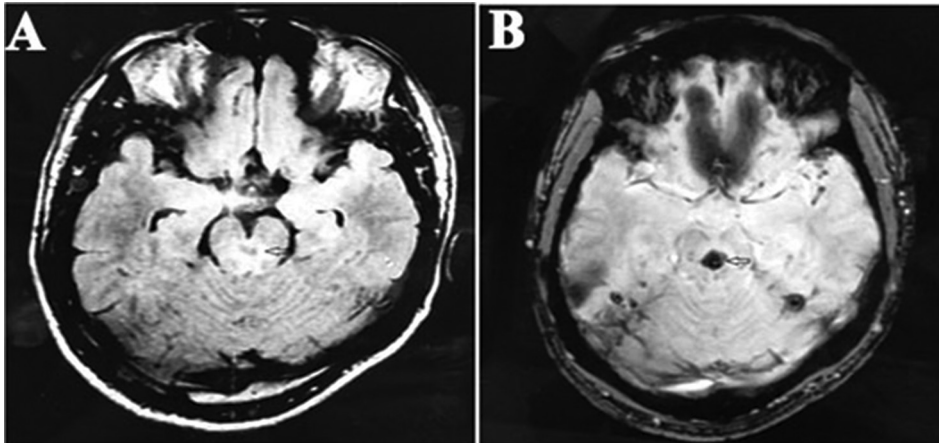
(A) T2WI/FLAIR showing hyperintense collection in midline of the mid-brain. (B) SWI (susceptibility-weighted image) showing blooming.
